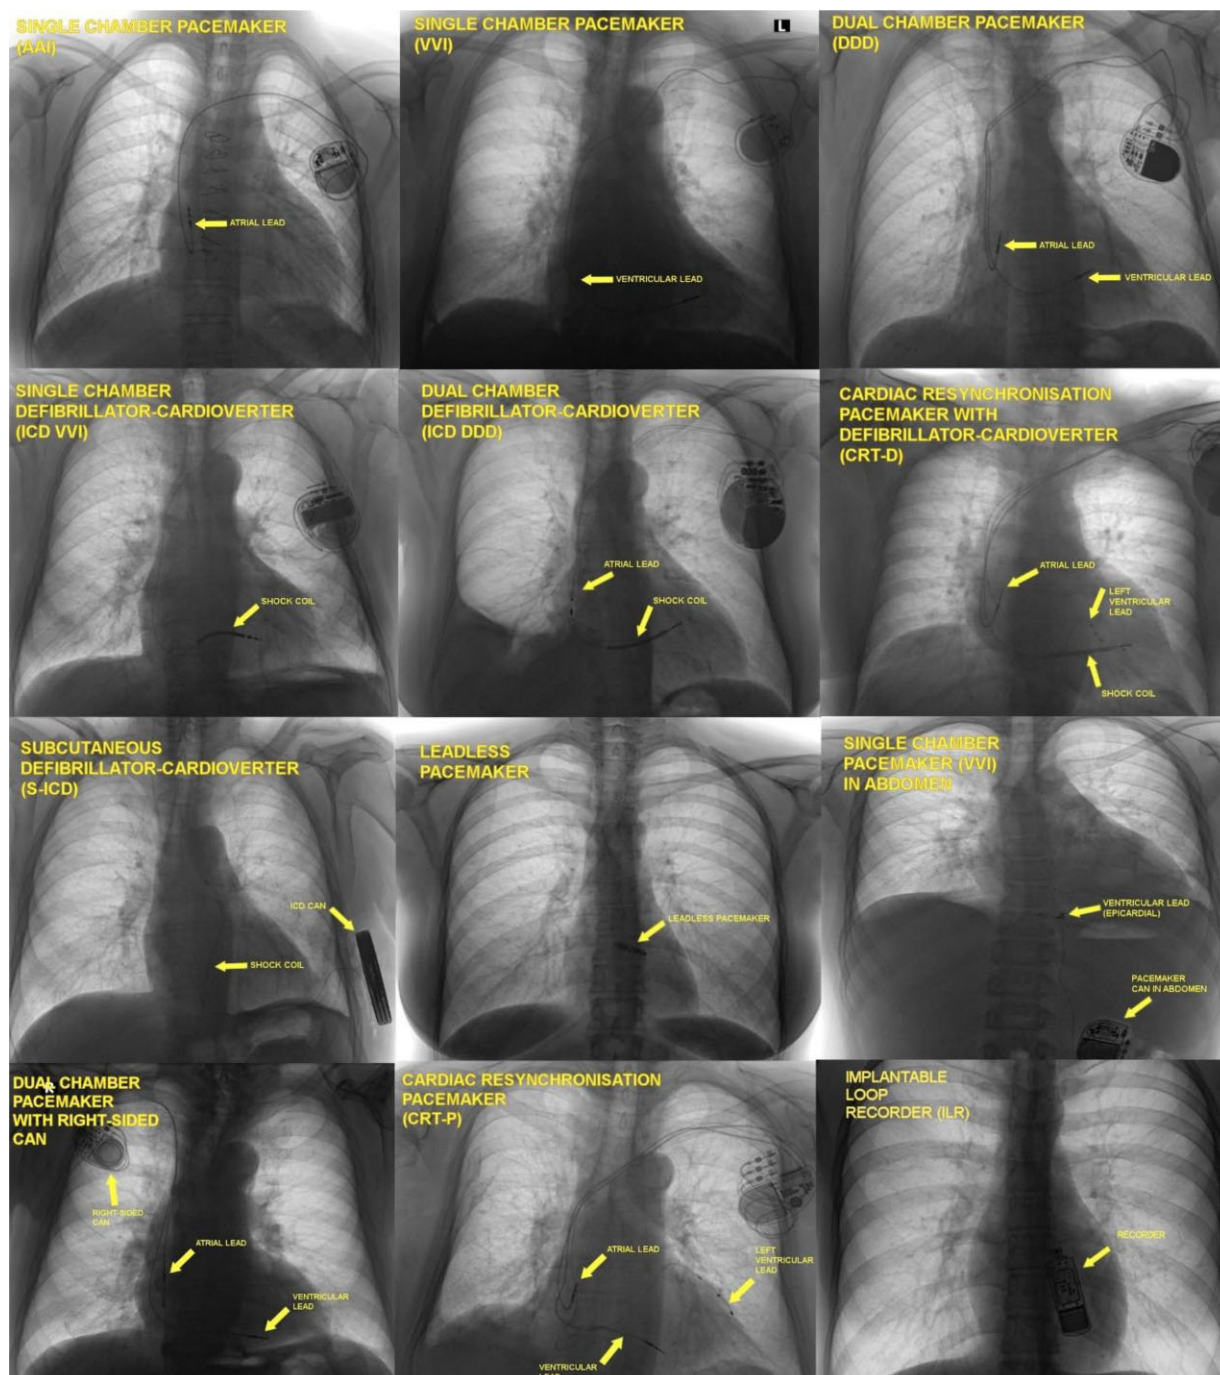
Chest X-ray to identify the type of CIED: typical X-ray pictures of the single-chamber PM (AAI, VVI), dual-chamber PM, single-chamber ICD, dual-chamber ICD, CRT device (PM and ICD), an S-ICD, a leadless PM, an epicardial PM and an implantable loop recorder (ILR) are shown; importantly, generators of transvenous devices can be implanted in a left and right pectoral pocket, a leadless PM is not equipped with a generator and the can of an S-ICD and an ILR are located on the left lateral thorax.
